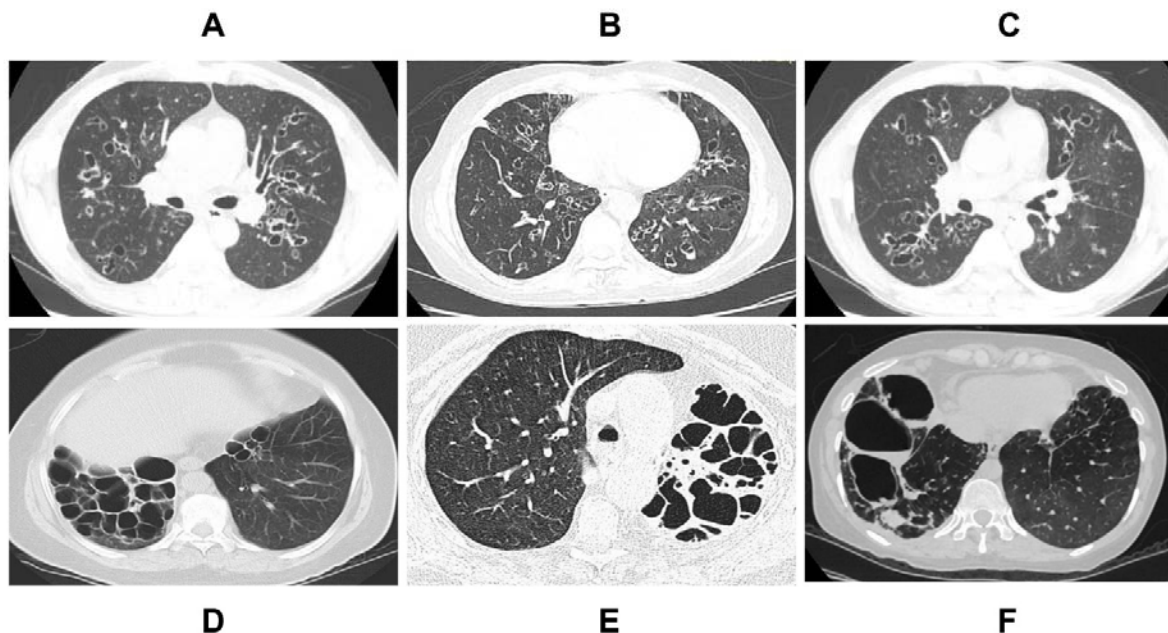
CT images from the EMBARC India registry from 6 randomly selected patients. Images A and B show predominantly cylindrical bronchiectasis. C demonstrates in addition varicose dilatation. D–F shows examples of severe cystic bronchiectasis representing the most frequently encountered imaging appearance found in this patient population.
